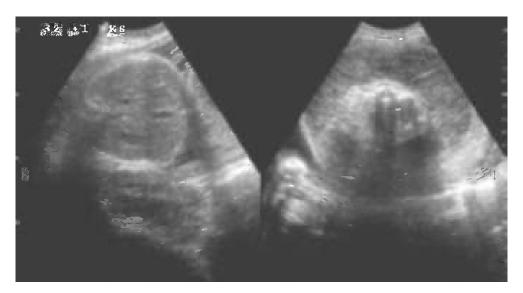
Characteristic third-trimester sonographic image of an acardiac twin (right). Note the vertebral column shown in this sonographic plane. Compare with the image of the 'pump' twin in the plane of the fetal liver (left)
